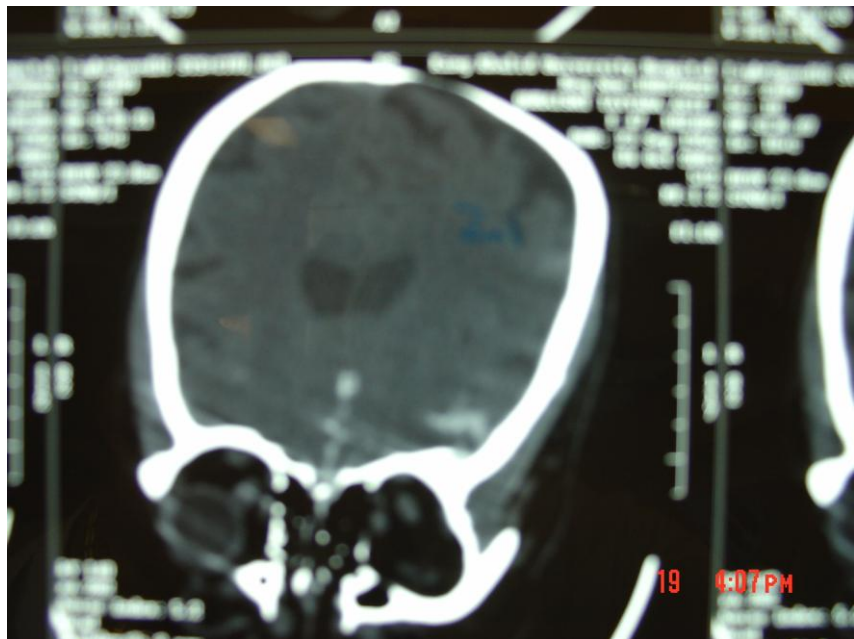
CT cisternography visualizing the site of CSF leak.
